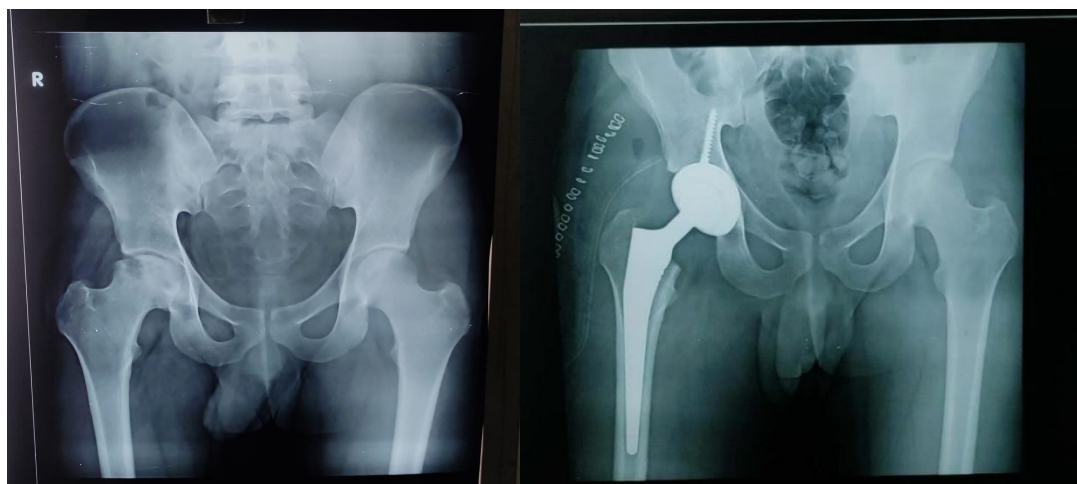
X-ray pelvis of 41 years female showing pre-op and post-op
